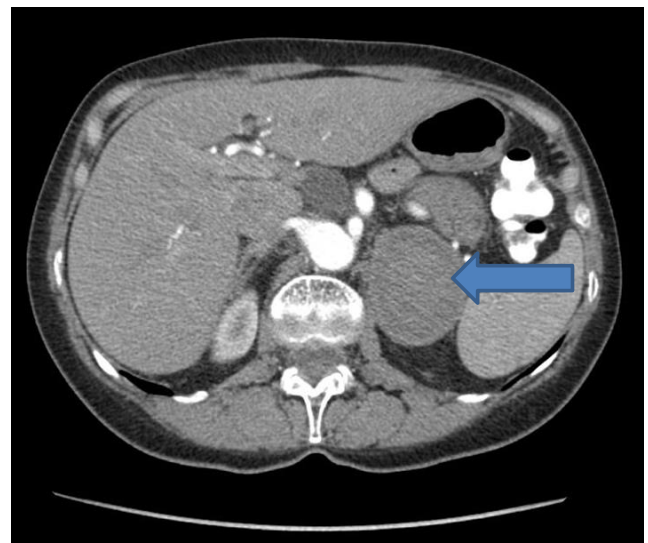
Patient No. 16: left adrenal hematoma, 60 mm in diameter (arterial phase CT scan)
